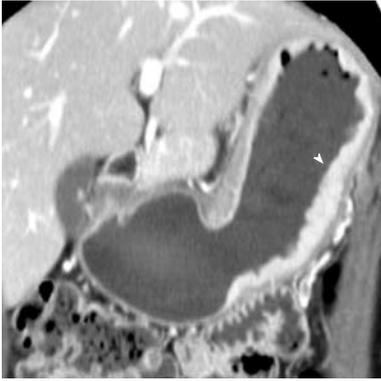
Signet ring cell carcinoma of the stomach in a 45-year-old woman. Coronal reformatted contrast-enhanced CT image shows diffuse gastric wall thickening with strong enhancement (arrowhead) along the lesser and greater curvature of the stomach. CT: Computed tomography.
